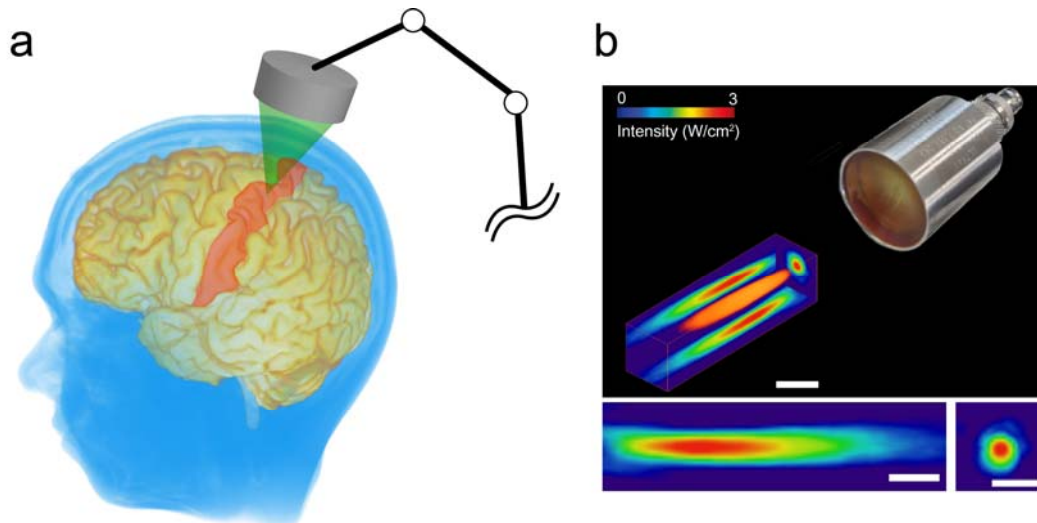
Transcranial focused ultrasound stimulation (FUS). (a) Concept of brain stimulation by FUS. (b) A single-element focused ultrasound transducer and its three-dimensional ultrasound intensity map. Scale bar 1cm.
